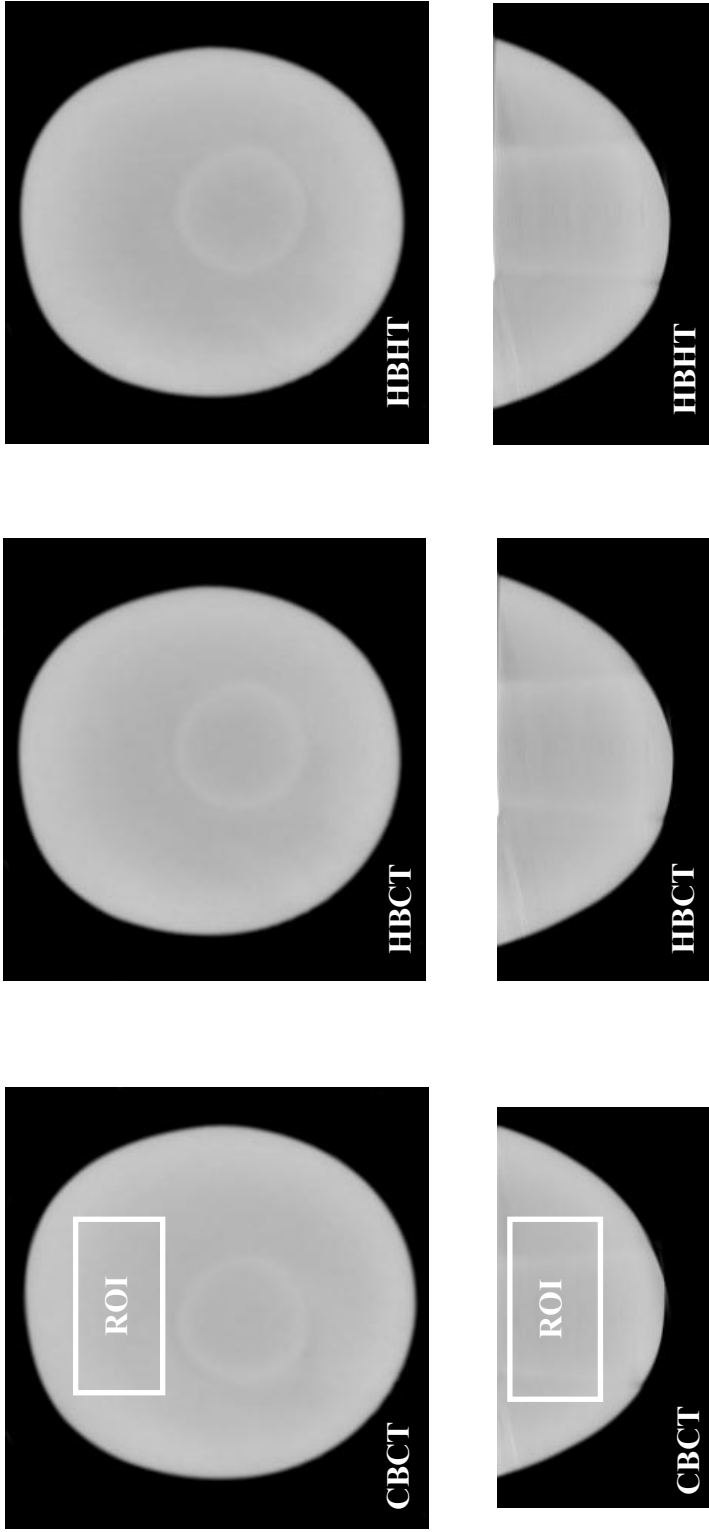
Reconstructed Breast CT data of the 1070 mL breast. (Top) Coronal and (Bottom) transverse slices are shown with some breast ROIs. Artifacts caused by the use of an offset CT geometry are visible in the coronal and transverse slices. These artifacts disappeared when a centered system geometry was employed in the integrated SPECT-CT system. The ROI used to measure SNR in the coronal viewpoint was placed in an artifact free zone.
